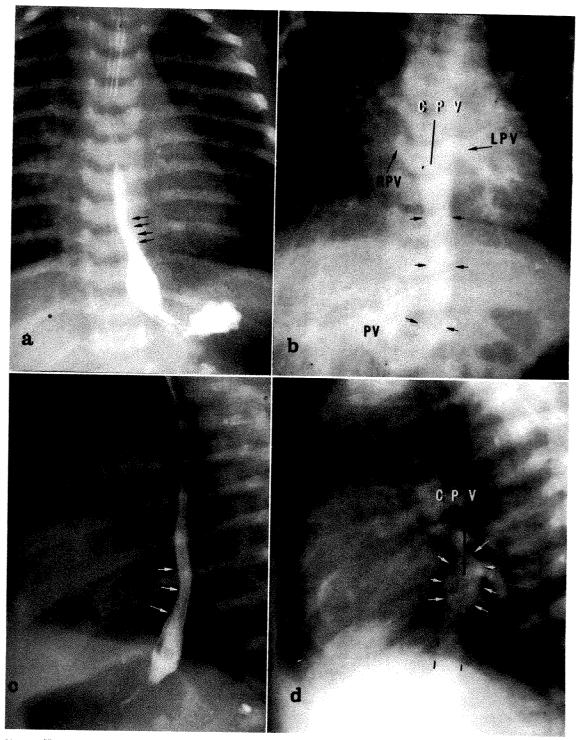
T.A.P.V.C. below the diaphragm in a 3 day old male. Abbreviations as in Figure 1. The posteroanterior (a) and lateral (c) chest roentgenograms show a low anterior indentation (arrows) in the barium filled esophagus owing to compression from the common pulmonary vein (CPV). The indentation in a is only suggestive. Venous phase of the anteroposterior (b) and lateral (d) angiocardiograms. The CPV is faintly opacified. It is situated immediately anterior to the esophagus and produces the aforementioned indentations. An anomalous vein (arrows in b) arises from the CPV, descends through the diaphragm and enters the portal system (PV).
